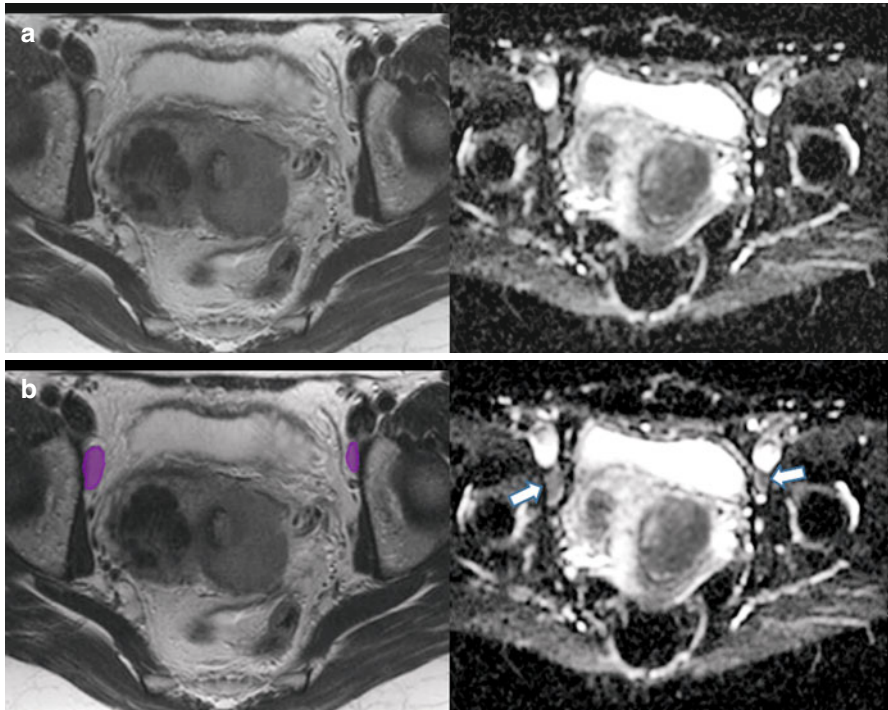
(a, b) Axial T2-weighted (*left image*) and ADC images (*right image*) showing bilateral metastatic obturator lymph nodes (*purple*) showing restricted diffusion in a patient with cervical cancer
